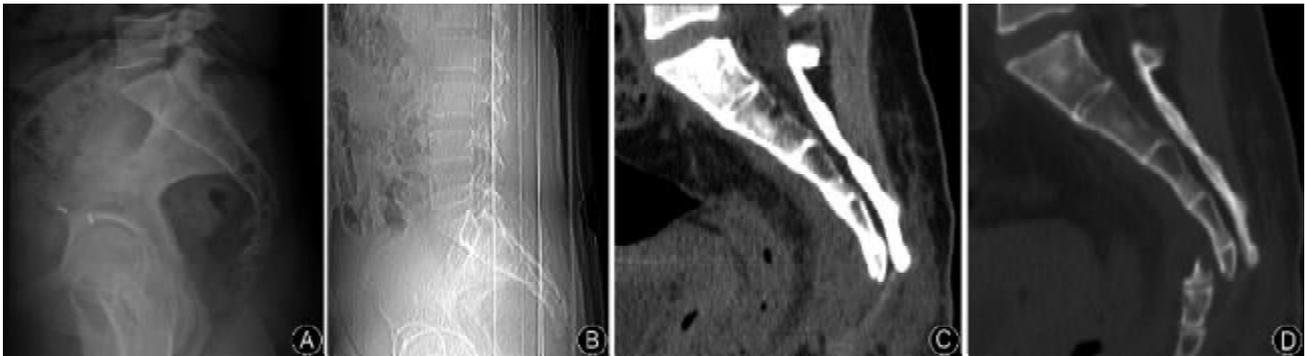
A 38-year-old woman suffered from coccydynia due to a traffic accident. She received coccygectomy after failed in conservative treatment for one year. Preoperative (A) and postoperative (B) lateral radiographs; preoperative (C) and postoperative (D) sagittal CT images.
